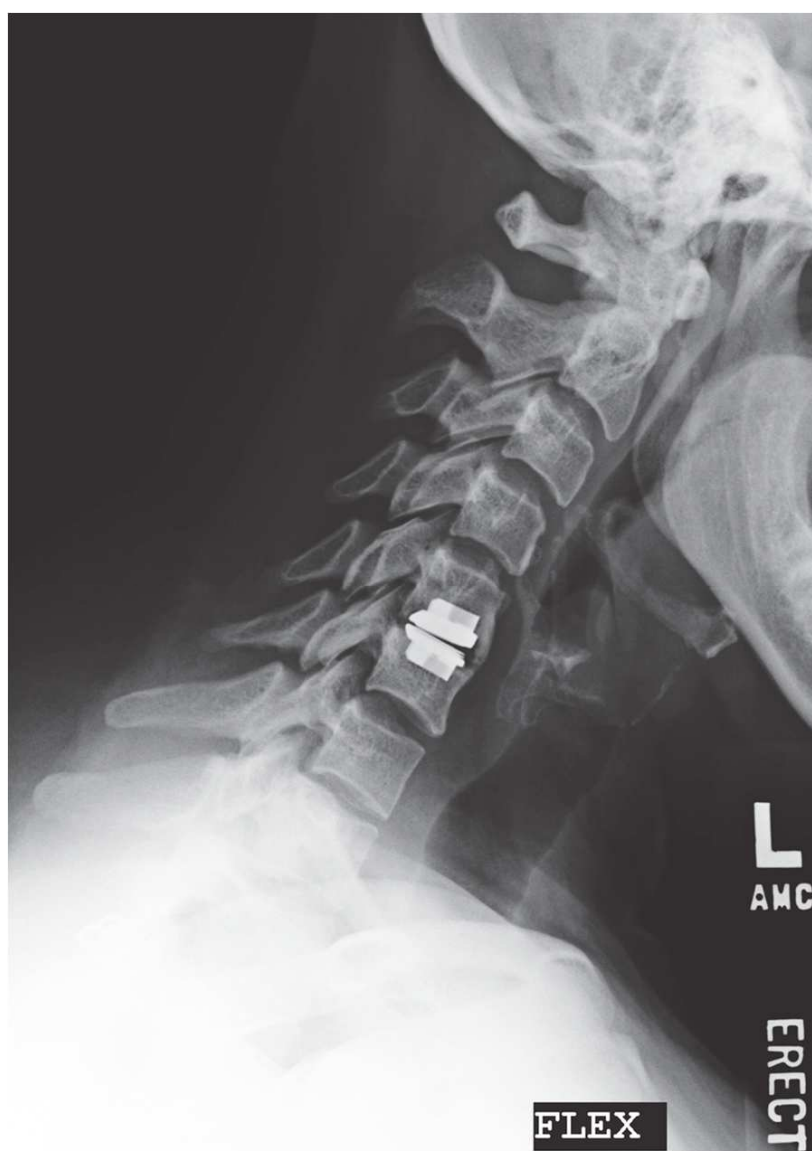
Lateral radiograph of ProDisc-C with HO formation and preserved motion
